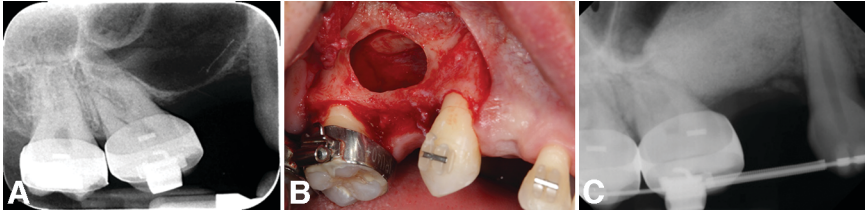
Lateral sinus lifting augmentation procedure during active orthodontic treatment. A: Pre-operative radiograph shows significant sinus pneumatization. B: Lateral sinus window with intact sinus Schneiderian membrane. C: Post-operative radiograph shows stable bone grafts in the sinus.
